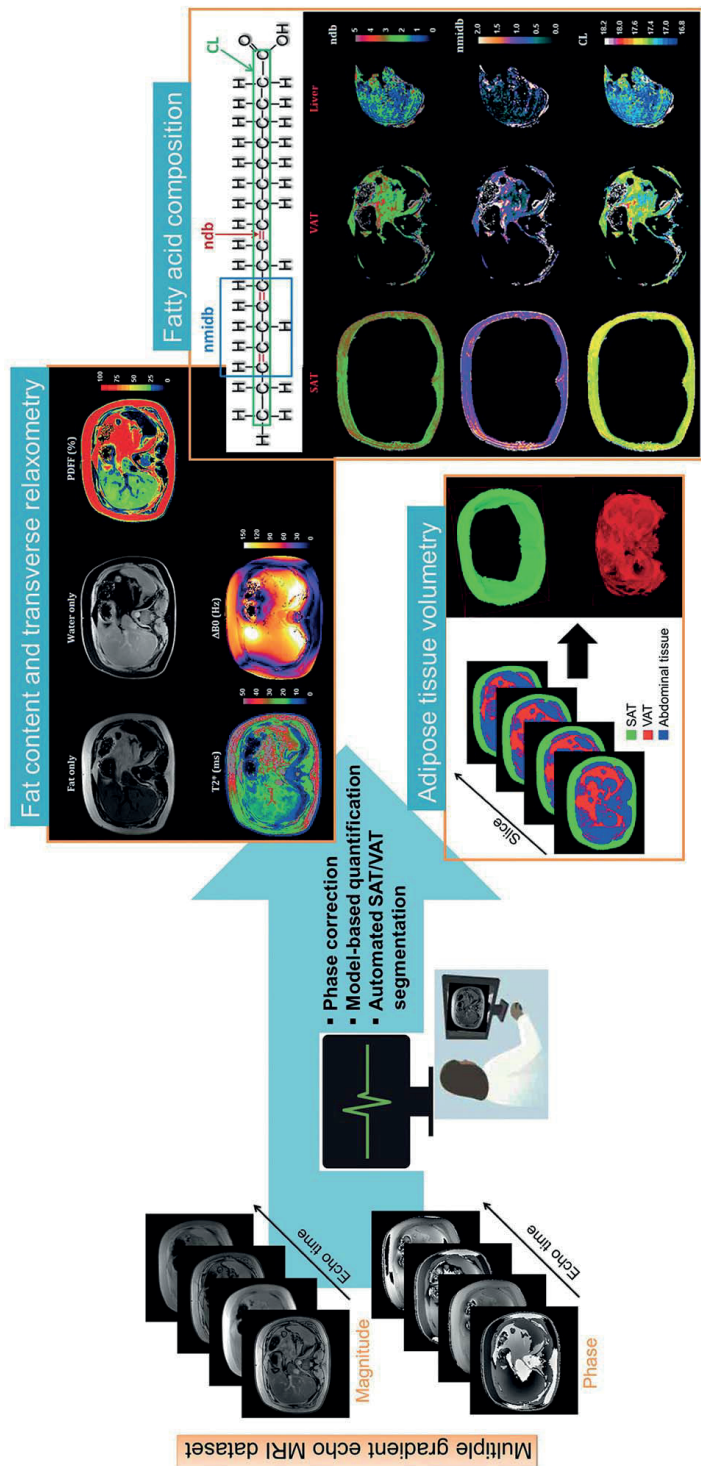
Different MRI approaches for the quantification of body fat distribution (32).
